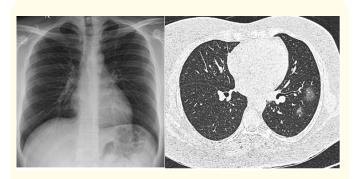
A and B: Pitfall Of X-Ray As Compared To HRCT Chest Where X-Ray Was Normal But HRCT Showed A Ground Glass Densities In The Left Lower Lobe.
